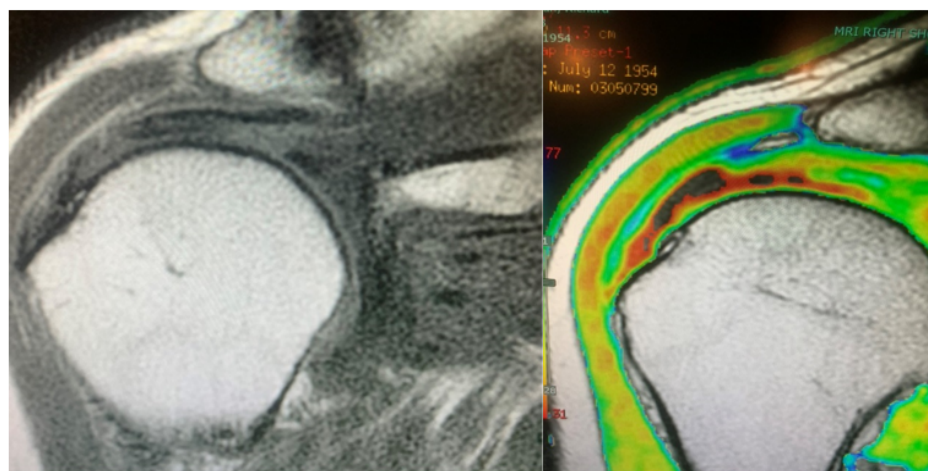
MRI and MR Cartigram® imaging of articular-sided Intrasubstance PTRCT of supraspinatus tendon at time of presentation.
